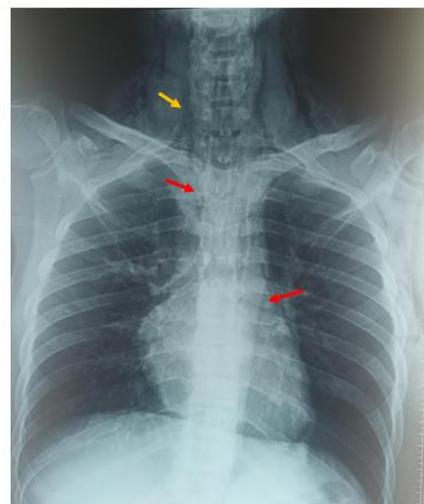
Front chest X-ray: showing pneumomediastinum (red arrow) with cervicothoracic soft tissue emphysema (yellow arrow)
